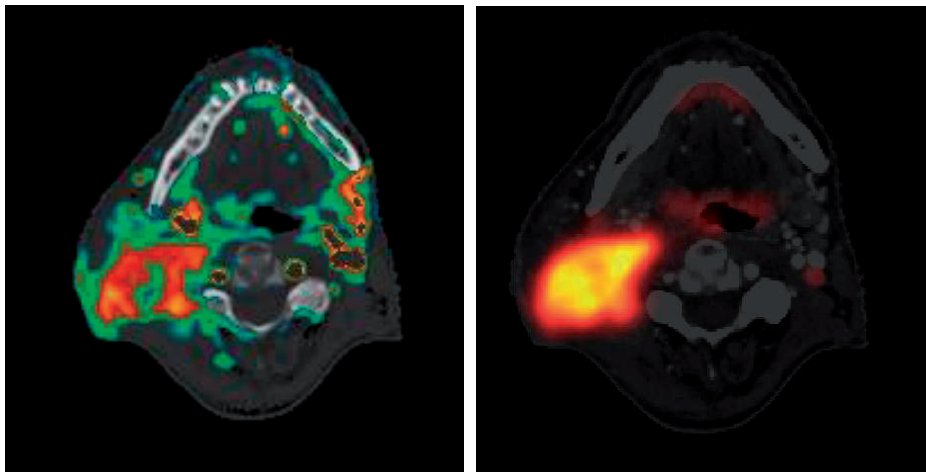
(Left) The image subtraction and overlay technique applied on CE-CT images of a human head and neck patient. The contrast enhancement in large blood vessels is set to zero. (Right) FDG PET/CT image of the same patient.
